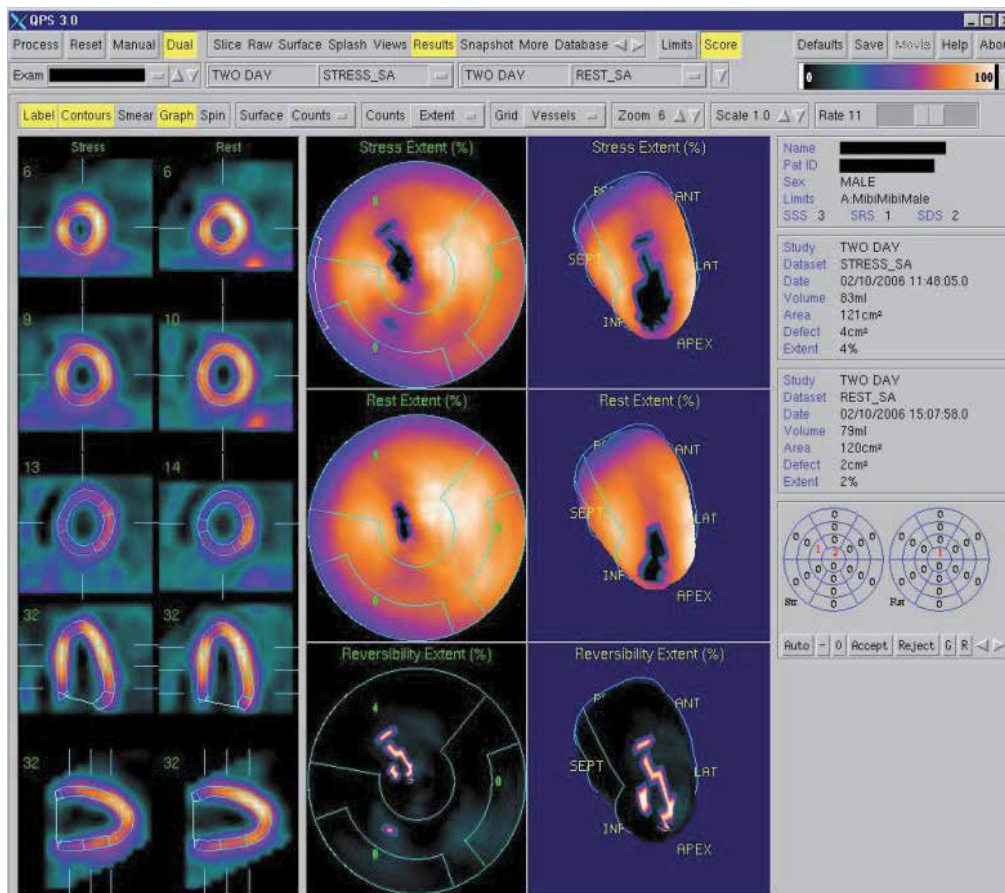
Myocardial scintigraphy - ischemic areas at the antero-septal wall and myocardial apex.
